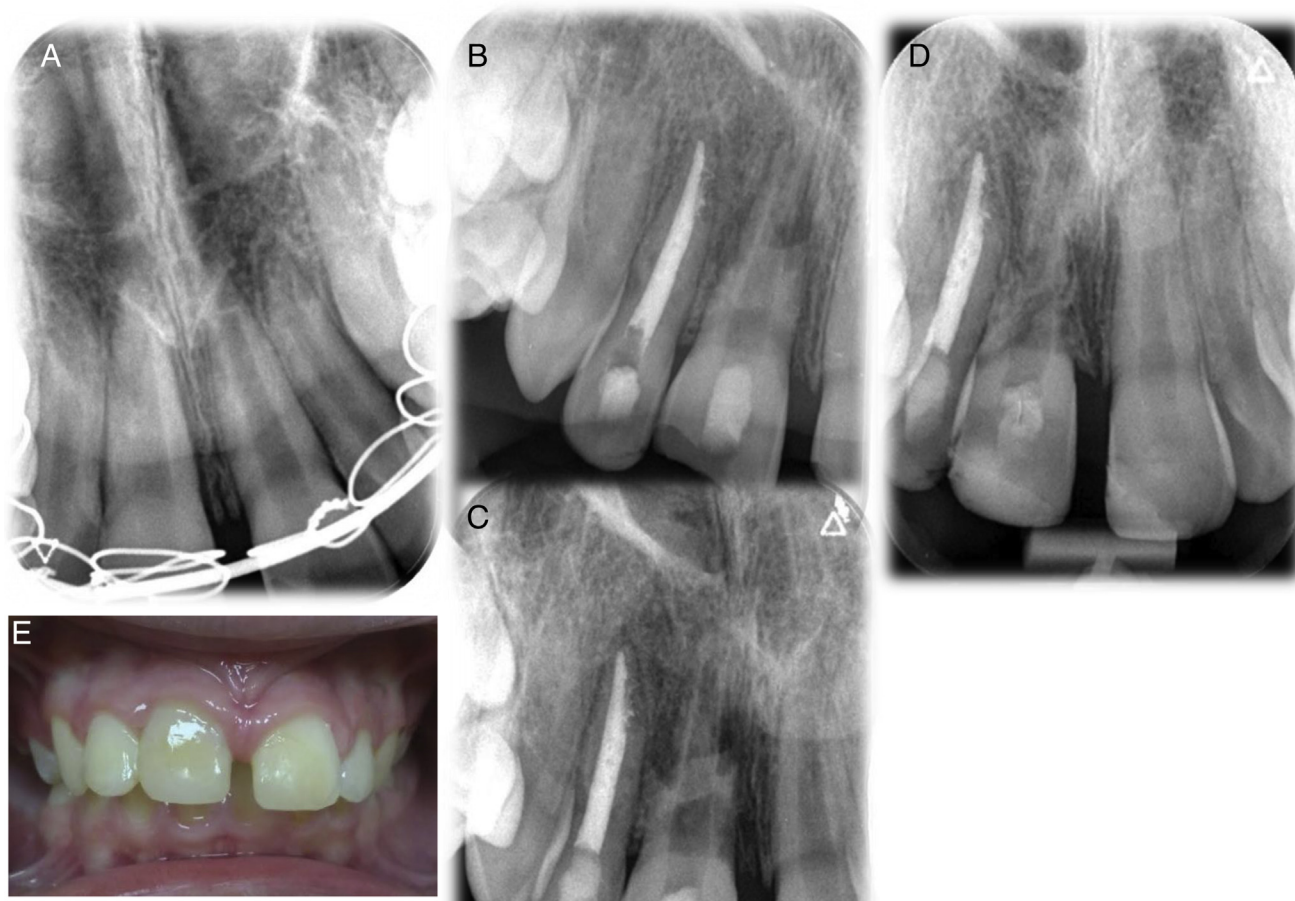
Endodontic regenerative treatment after recent avulsion and reimplantation of tooth #8. (A) The periapical radiograph of tooth #8 showing the Erich arch splint. (B) The preoperative periapical radiograph taken 6 months after the event. Notice a massive root resorption beginning from the midroot to the apex. (C) The periapical radiograph taken upon finishing the PRF insertion. (D) The 12-month follow-up periapical radiograph. (E) A clinical view of the front upper teeth; there is no discrepancy in the cervical line of the crown of tooth #8 and the neighboring crowns.
